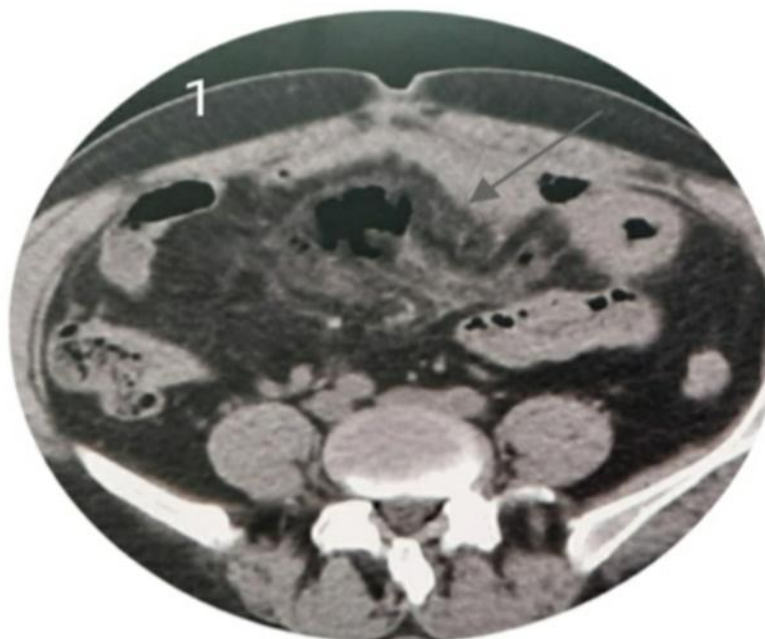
Axial CT scan showing soft tissue mass involving small bowel mesentery.
